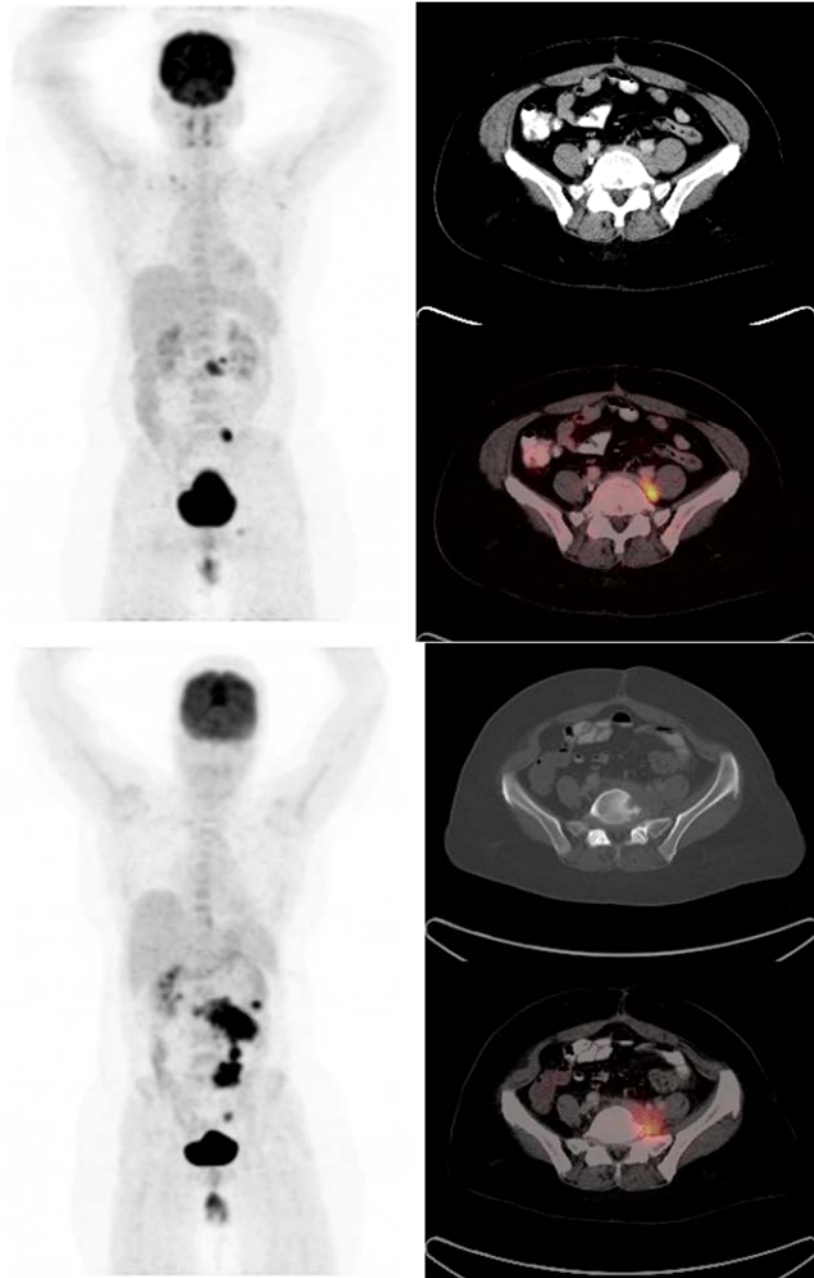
A 38-year-old HIV-uninfected female who previously had total abdominal hysterectomy plus lymph node dissection for a FIGO stage IB carcinoma of the cervix. ^{18}F -FDG-PET/CT obtained on account of clinical concern for recurrence show metastatic left para-aortic and iliac nodes (top row). No treatment was given following the initial PET/CT scan. A repeat ^{18}F -FDG-PET/CT scan obtained 11 months later show increased in size and ^{18}F -FDG avidity of the previously reported metastatic nodes with invasion into the adjacent L5 vertebra (bottom row). New metastases sites are seen in the anterior abdominal wall and pelvic node.
